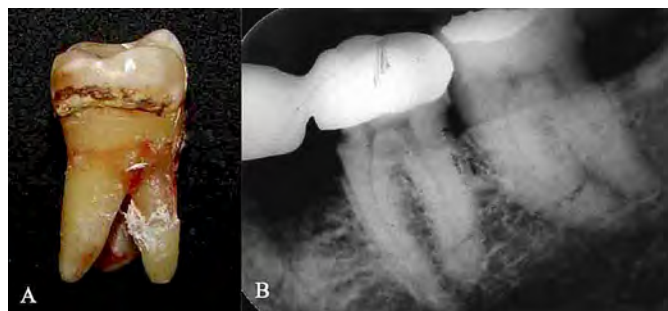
(Left) An extracted mandibular left third molar with a radix entomolaris. (Right) Radiograph of the mandibular right third molar showing only presence of two roots. Case is a 54 year old male.
